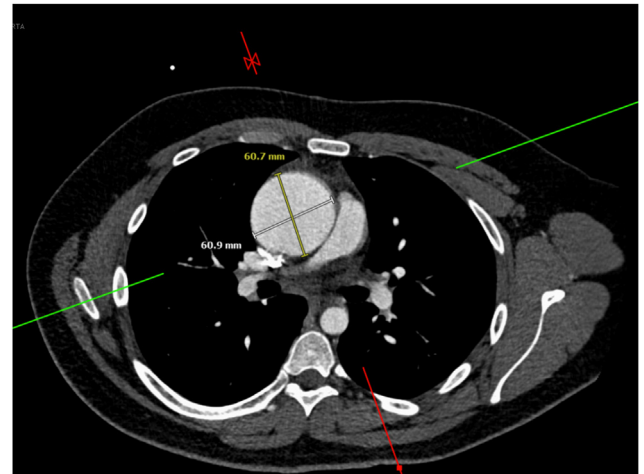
Computed tomographic angiography of the chest, transverse section, demonstrates the aneurysm of the ascending aorta.
